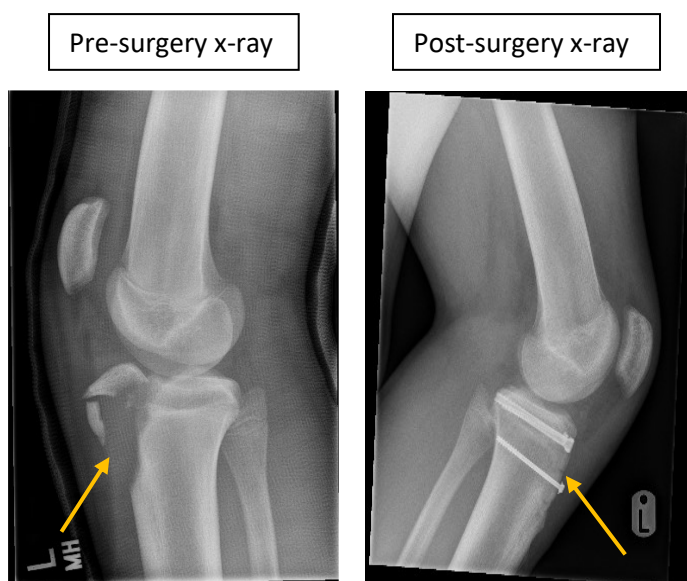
Player A pre- and post-surgery lateral x-rays of the left proximal tibial avulsion injury.
